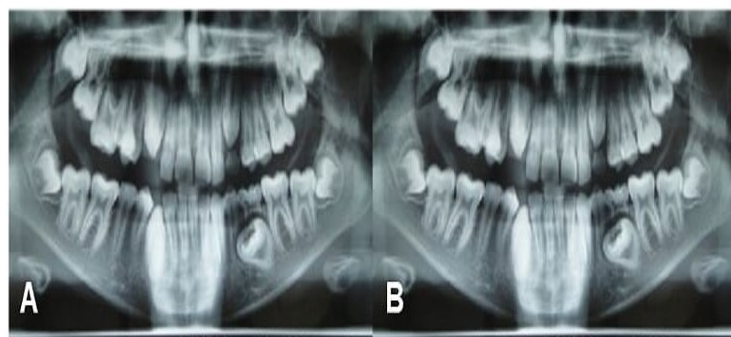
(A) Pre-operative panoramic radiograph; and (B) after 60 days. Note (in B) the eruption of some permanent teeth after the resective surgical procedures
